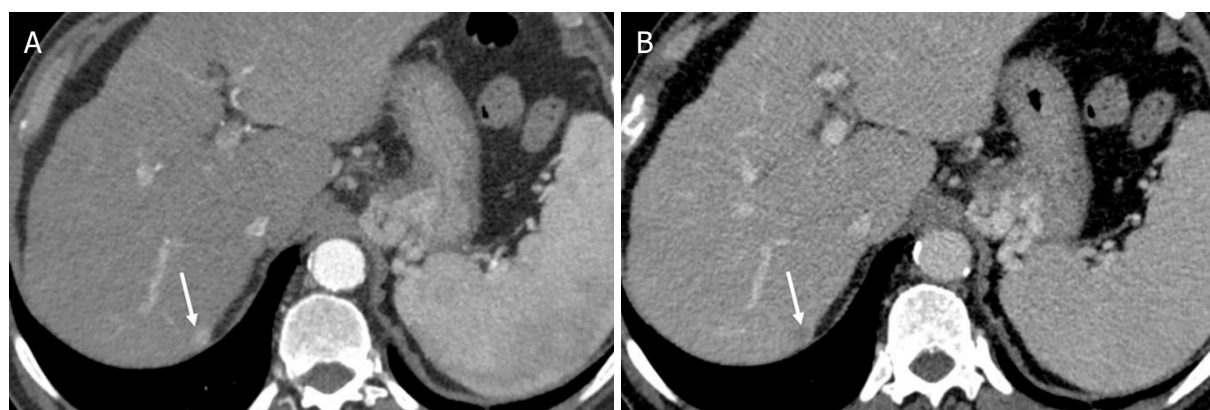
LR-4 (Probable hepatocellular carcinoma). Axial computed tomography in a 68-year-old man with hepatitis C cirrhosis. Arterial phase (A); and portal venous phase (B) demonstrate a 9-mm observation with nonrim arterial phase hyperenhancement [arrow (A)], nonperipheral washout appearance [arrow (B)], and no enhancing capsule appearance
